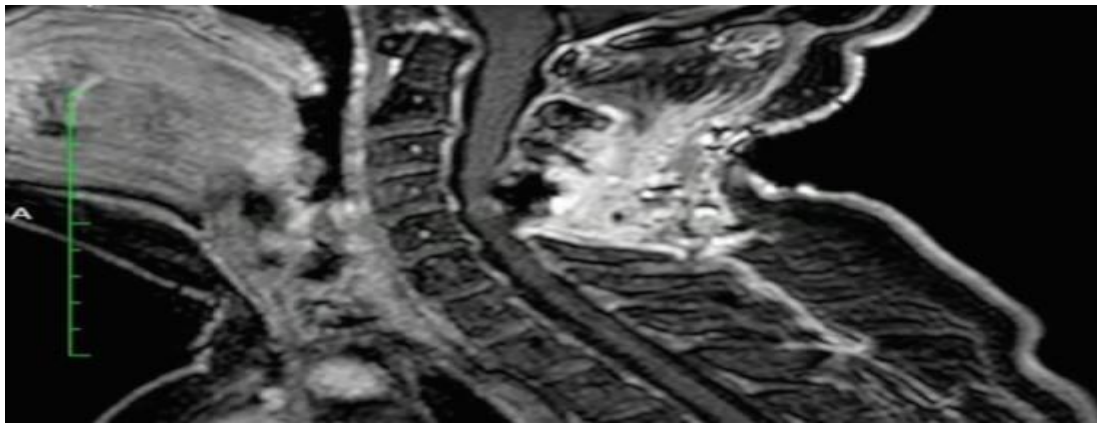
Six months postoperative MRI (5).
